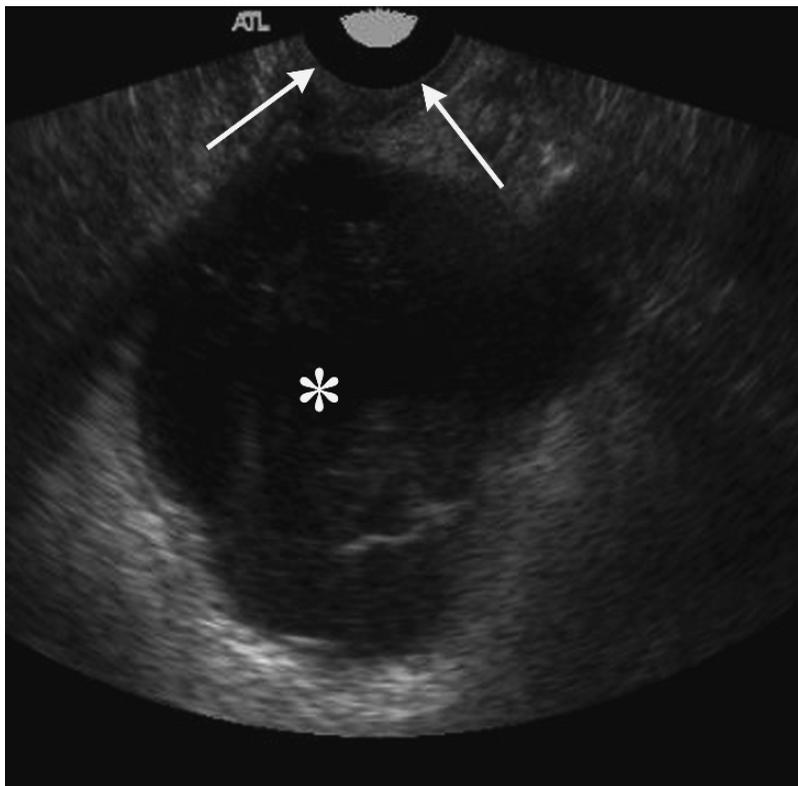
Transrectal abscess drainage. The ultrasound probe (arrows) will guide placement of a drain into the pelvic abscess (*).
